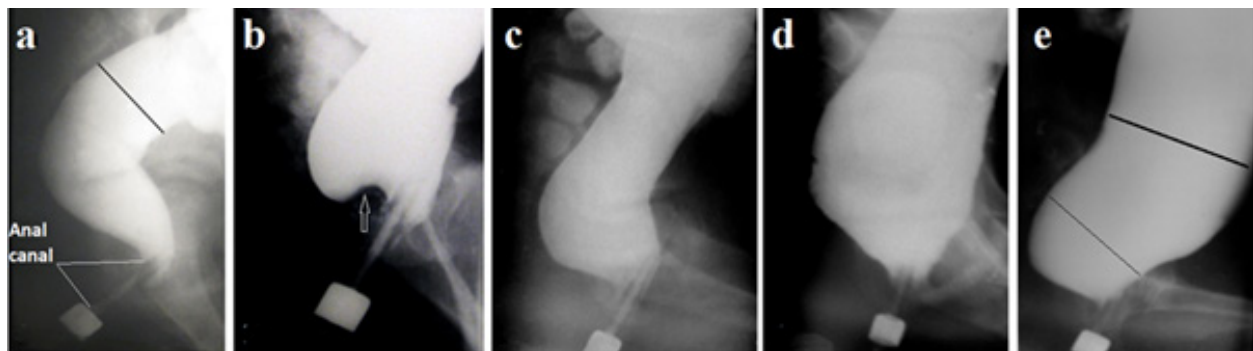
Lateral radiographs of the anorectal region in patients with varying degrees of megacolon compared with normal.
